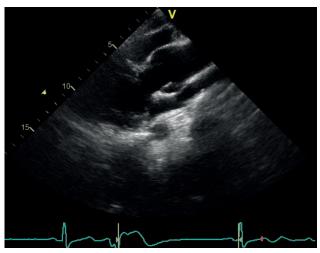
B-mode echocardiogram: aortic dilation at the level of the sinuses of Valsalva.
